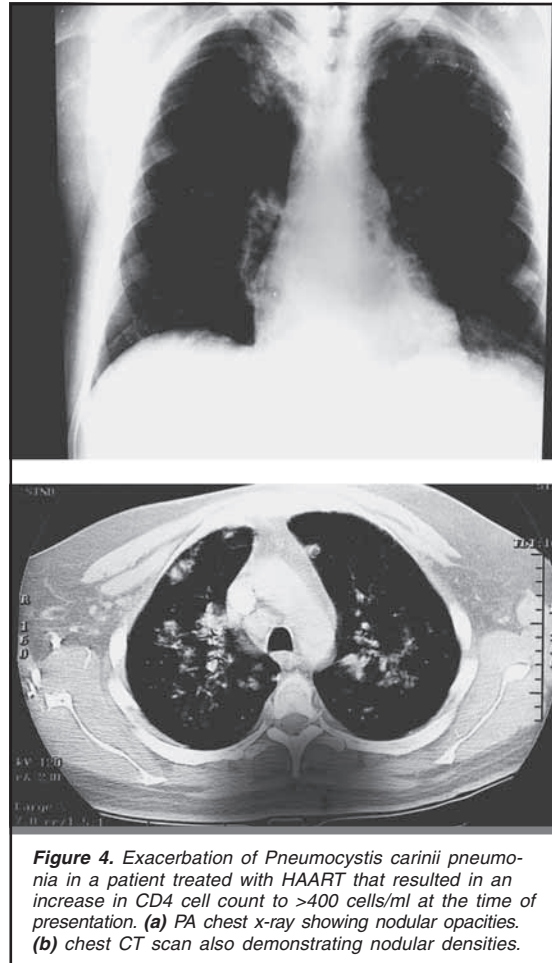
Exacerbation of *Pneumocystis carinii* pneumonia in a patient treated with HAART that resulted in an increase in CD4 cell count to >400 cells/ml at the time of presentation. (a) PA chest x-ray showing nodular opacities. (b) chest CT scan also demonstrating nodular densities.
